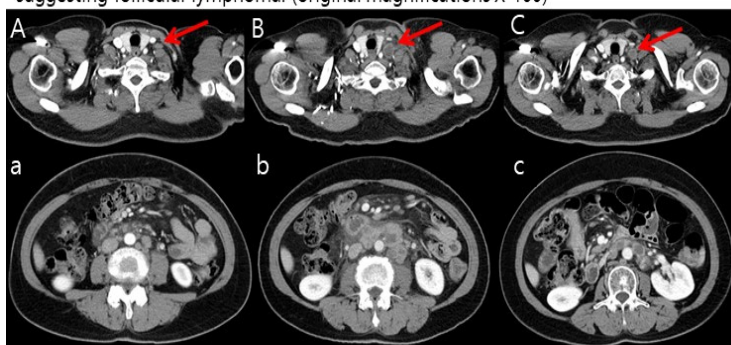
Computed tomography(CT). Initial chest CT (A) and abdominal-pelvic CT (a) showed enlarged lymph nodes in multiple regions including left supraclavicular lymph node (arrows). Images (B, b) after four month of "Watchful waiting" showed worsening lymphadenopathy. Images (C, c) after 2 cycle of chemotherapy showed improving lymphadenopathy.
